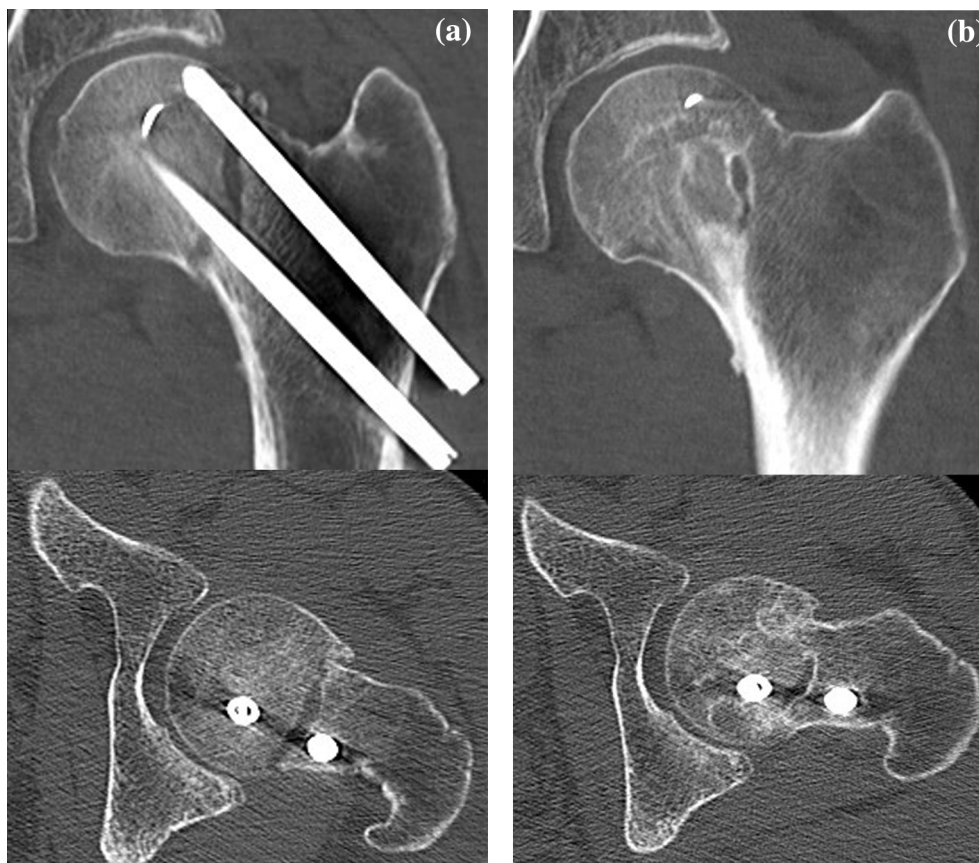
(A) CT scan taken 13 weeks post-surgery showing the absence of trabecular bridging, which indicates delayed union of the femoral neck. (B) A CT scan taken 9 months post-surgery (6 months after the initiation of LIPUS treatment) showing bony union of the fracture.
